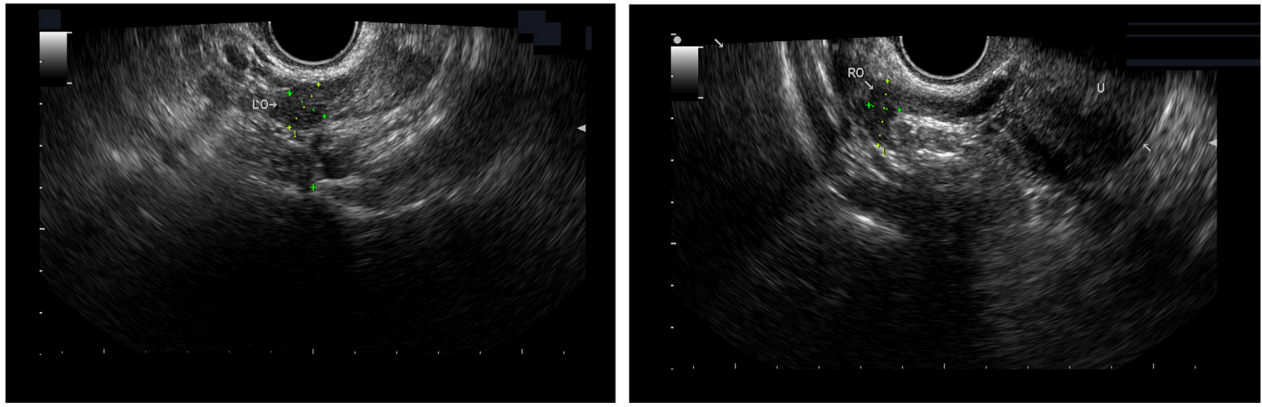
Transvaginal ultrasound examination of the proband showing that the bilateral ovaries are abnormally small, and no obvious antral follicles are observed. LO, left ovary; RO, right ovary.
